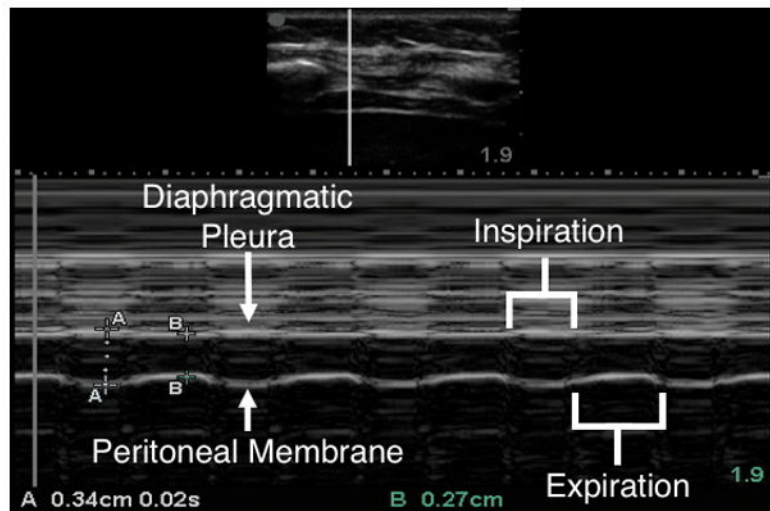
M-mode Ultrasound Measurement of Diaphragm Thickening Fraction at the Zone of Apposition.
